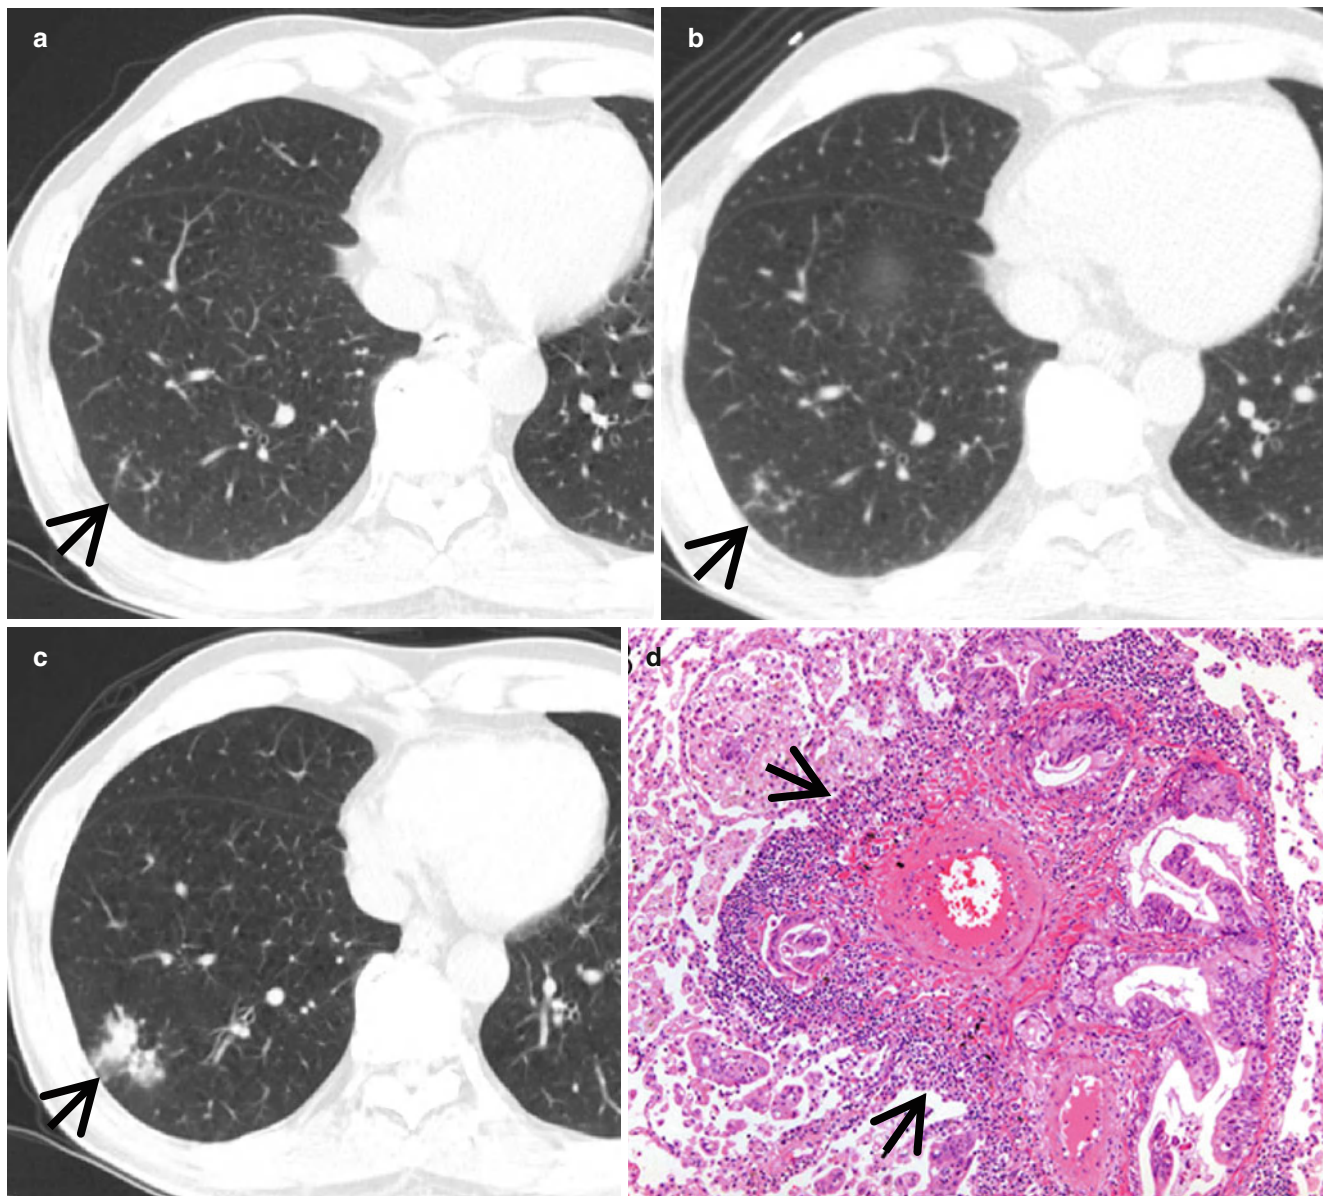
Lymphangitic metastasis along bronchovascular bundles manifesting as vascular tree-in-bud sign in a 59-year-old man who has pancreas head cancer. (a–c) Lung window images of serial CT scans obtained at same level over the follow-up period of 6 months show evolving lung lesion from tree-in-bud sign (arrows in a and b) to localized area of lobular
